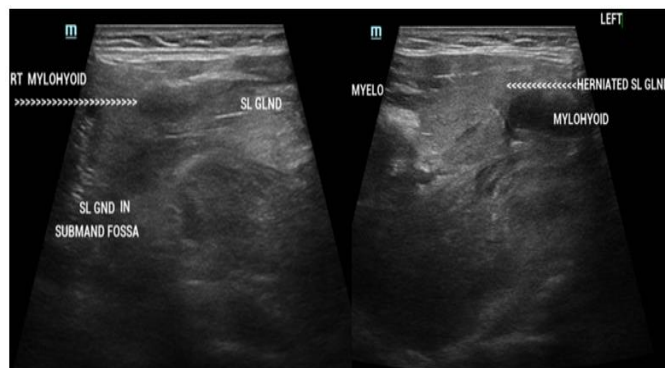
Transverse sonograms showing (A) the enlarged right sublingual gland extending into the submandibular fossa(B) Enlarged left sublingual gland herniating through defect in mylohyoid.
